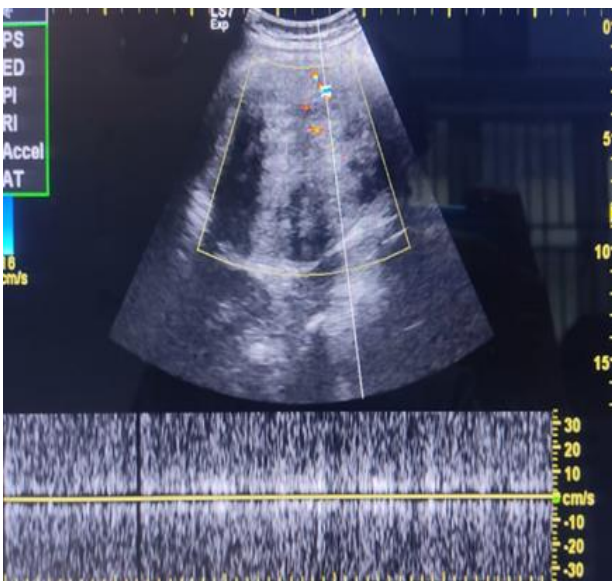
Ultra sonogram image of large fibroid with no internal vascularity.
